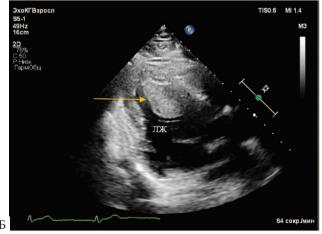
Transthoracic echocardiography of patient
